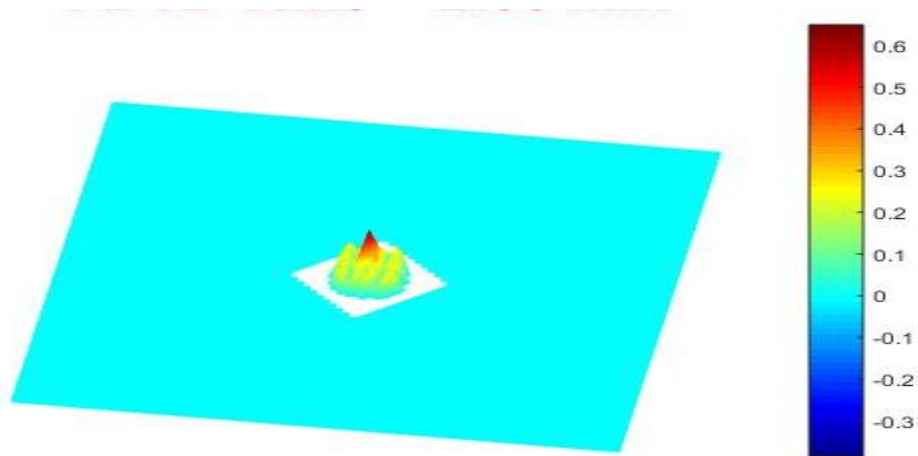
Head Temperature during Brain MRI, $t = 2.06$ minutes.
